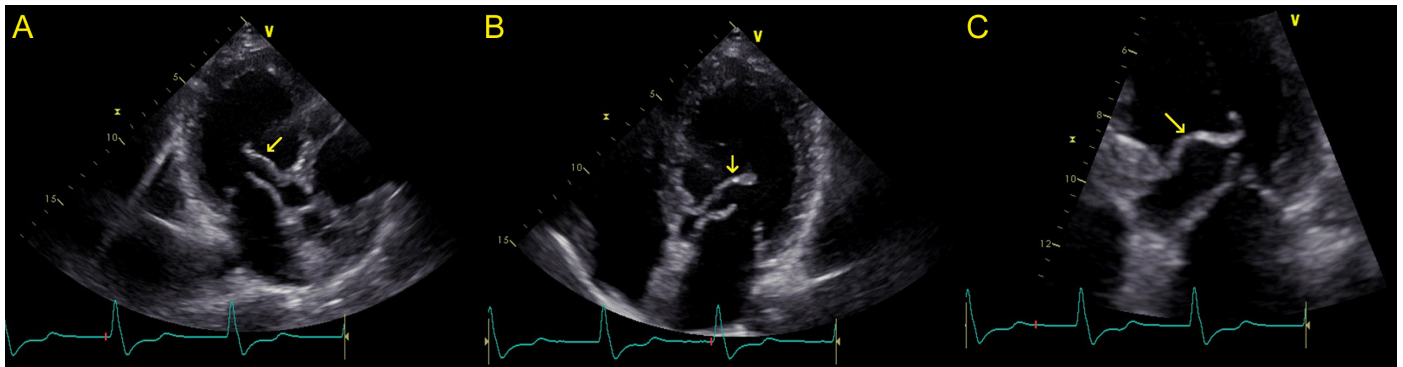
The transthoracic echocardiographic appearance of the accessory mitral valve (yellow arrows) in apical 3-chamber view (A), apical 4-chamber view (B), and a zoomed image in apical 4-chamber view (C).
